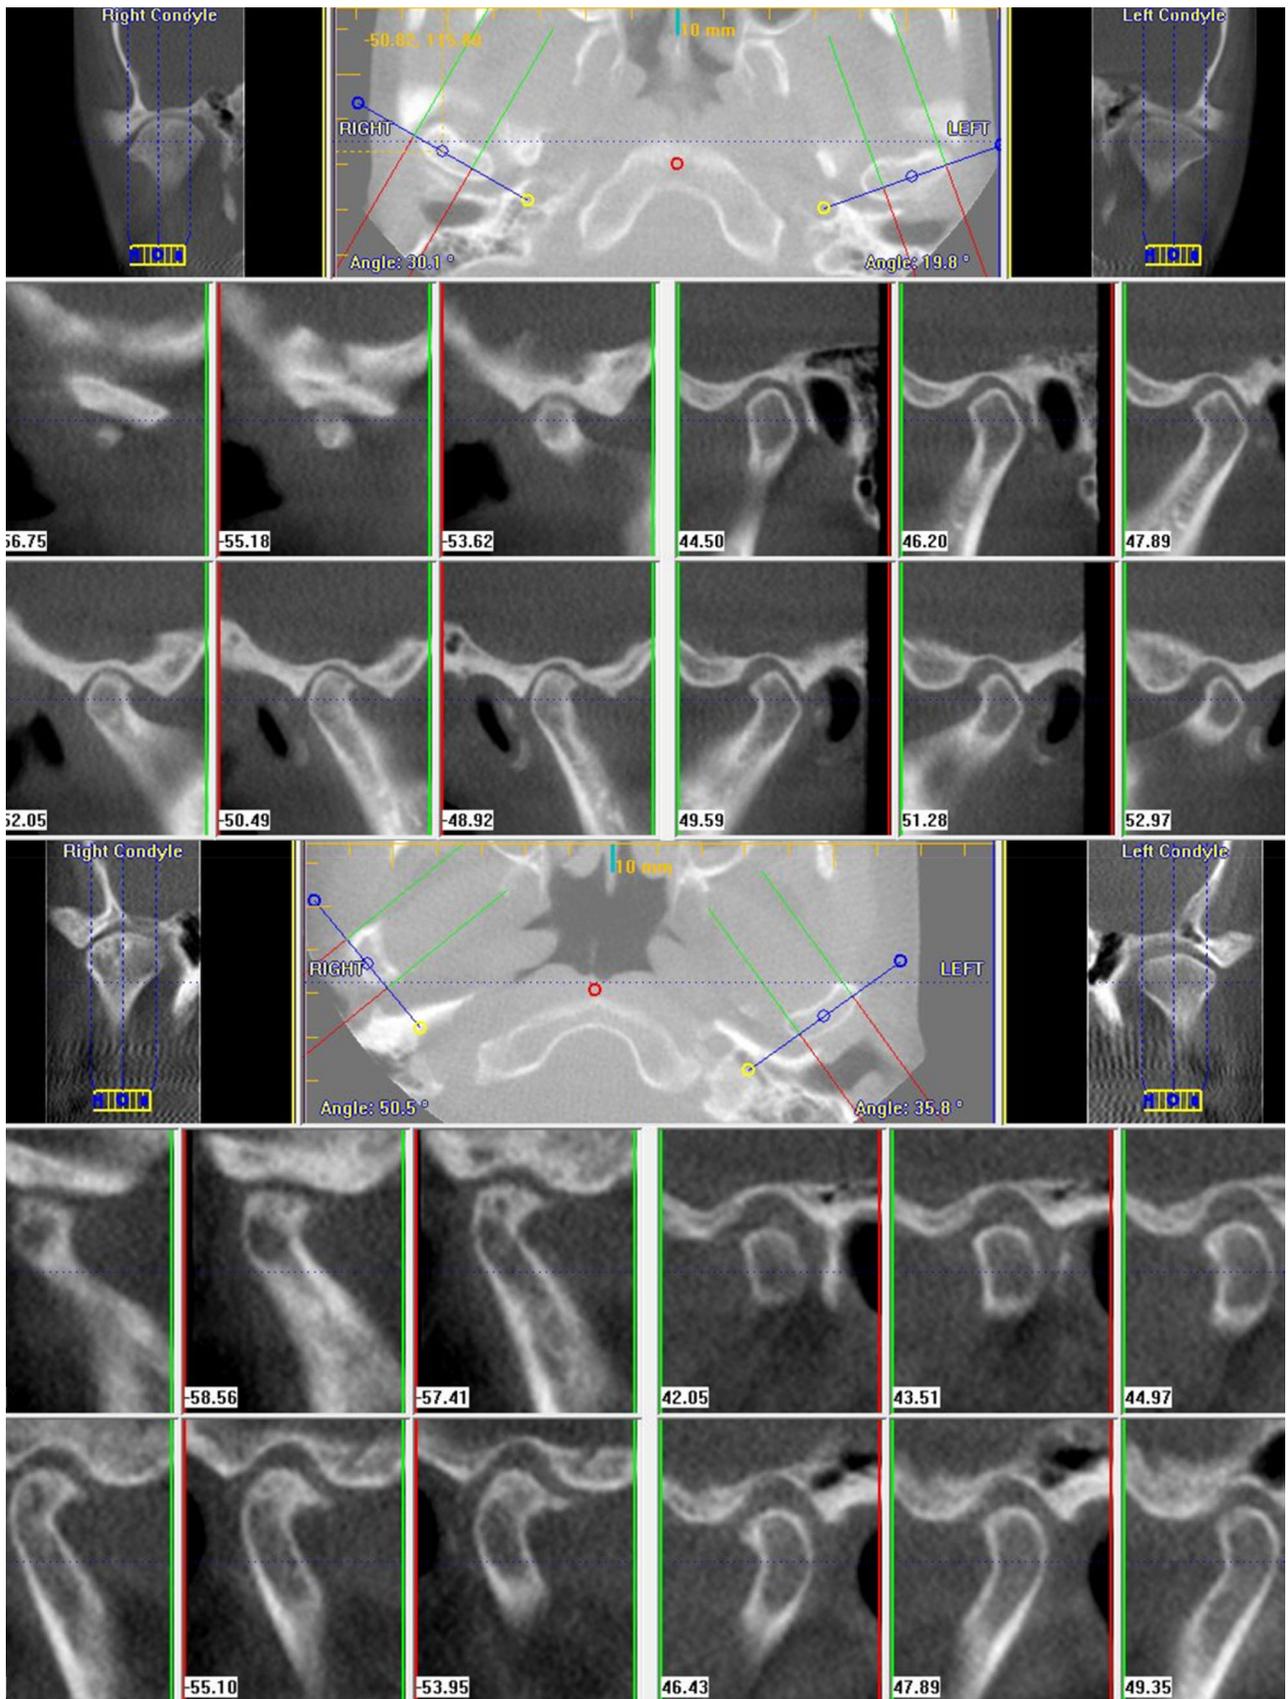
TMJ coronal and sagittal views of two cases of TMJ osteoarthritis—one with unilateral involvement and other with bilateral TMJ OA. Both are taken with ICAT(R) CBCT machine and displayed with ICATvision software. The condyles show typical OA changes namely flattening of the superior surface, loss of joint space of the affected joints, bird-beaking and generalized sclerosis of the articular surfaces. Most commonly, there will be changes to the articular eminence as well
